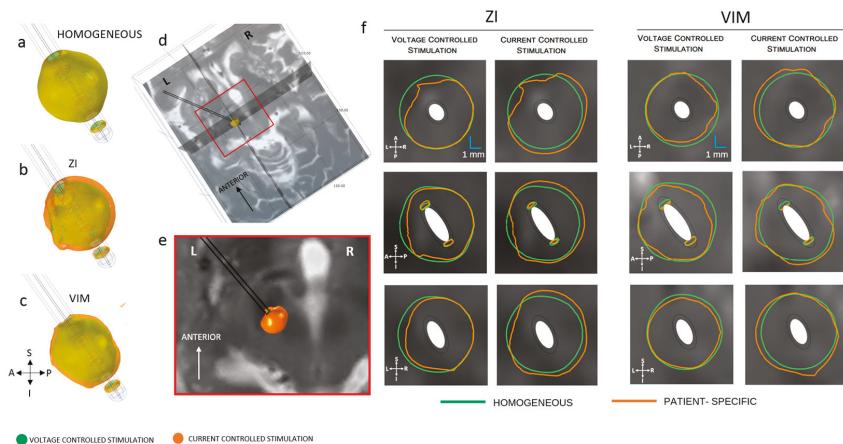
Electric field (EF) distribution (0.2 V/mm) in voltage and current control stimulation mode. (a) Homogeneous model (b) patient-specific model, ZI and (c) VIM; (d) Axial, sagittal and coronal cut planes, crossing at the middle point of the active contact (e) closer view of the axial plane of the preoperative MRI at the ZI and (f) electric field isocontours (0.2 V/mm) of lead 3389 for homogeneous and patient-specific brain models. EF obtained at 3 V (first and third column) and 3.4 mA (second and fourth column). A: anterior, P: posterior, S: superior, I: inferior, L: left, R: right.
